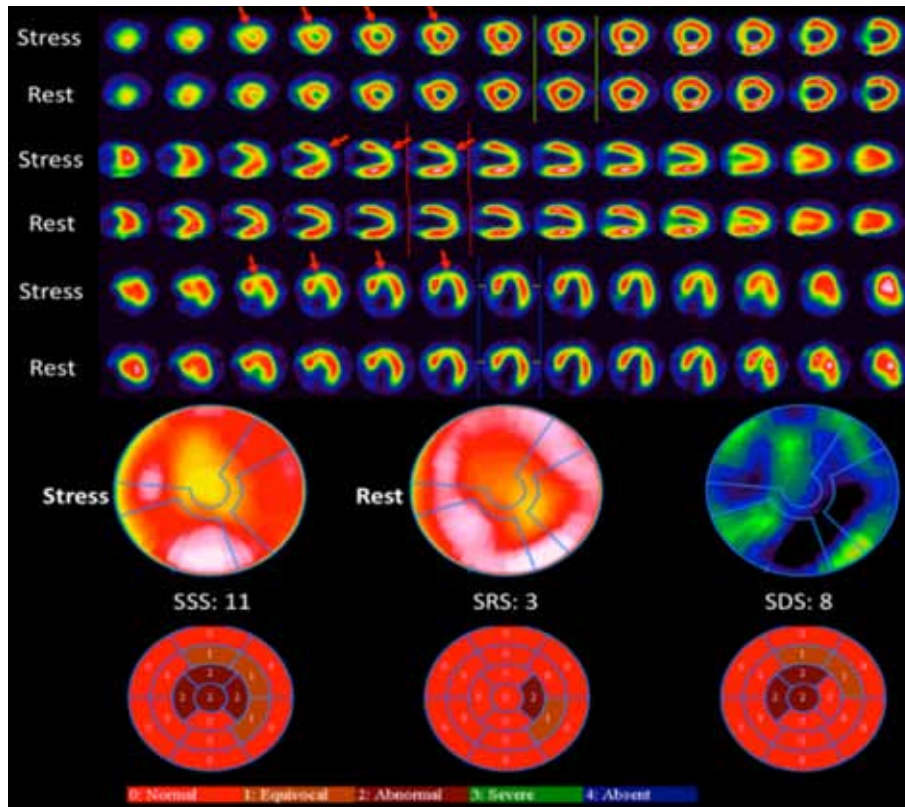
Myocardial perfusion scintigraphy demonstrating ischaemia.
